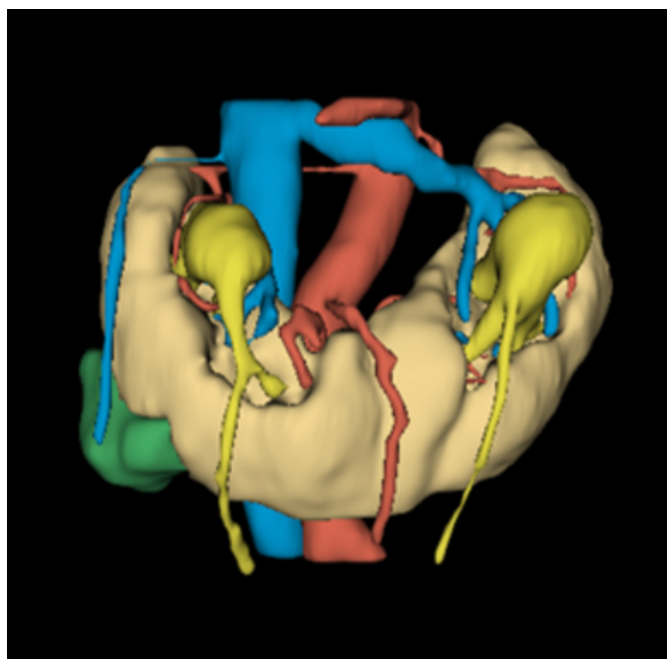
3D reconstruction of the CT scan viewed in coronal plane (left) and sagittal plane (right) showing the kidney, the renal mass (green), the arterial (red) and venous (blue) vascularization and the urinary collecting system (bright yellow)
